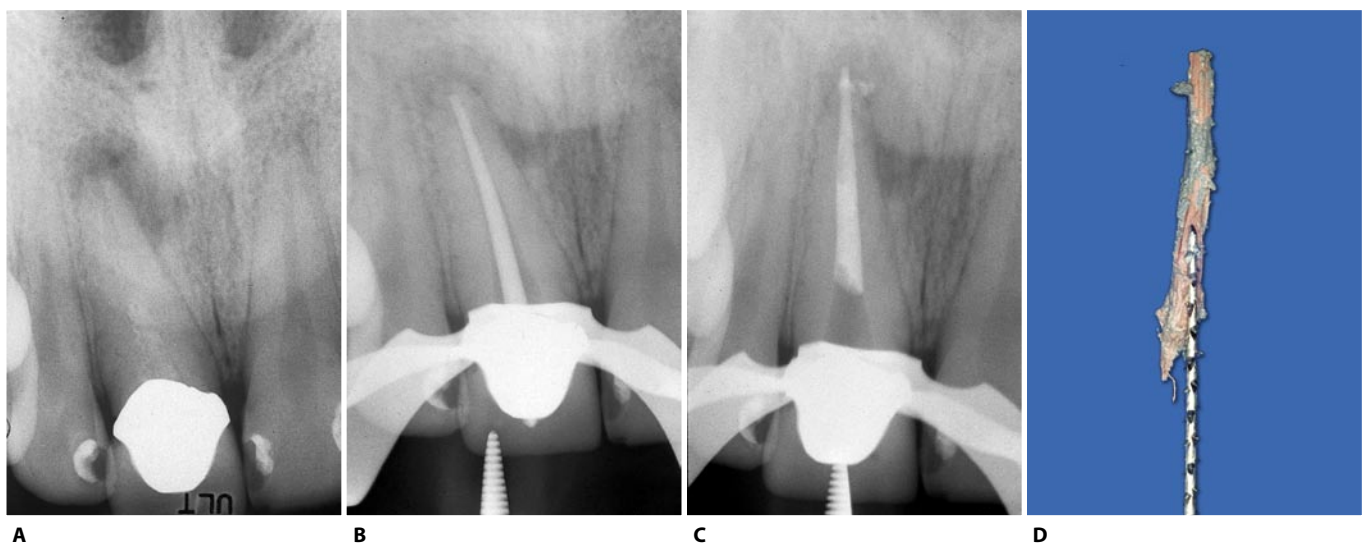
Owing to a previous improperly performed shaping, the cone introduced and compacted traditionally had a tug back in the middle third rather than the apical third, with a subsequent inevitable extrusion beyond the apex. The case was therefore completed with the use of the Obtura syringe according to the sectional technique, after the removal of the gutta-percha extruded in the periapical tissues. A. Preoperative radiograph. B. Radiograph of the cone fit. Clinically, the cone presents a tug-back. C. Evidently, the tug-back was in the middle third. Once this point was overcome, the cone slid beyond the apex without however sealing the foramen. D. With a large barbed broach, the gutta-percha cone was immediately removed from the canal (continued).
